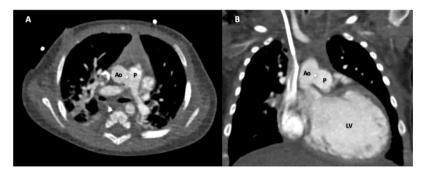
Computed tomography. Axial (A) and coronal (B) views, in which a large (10 mm×10 mm) aortopulmonary window is evident (*). The left ventricle is severely dilated. Ao: ascending aorta; P: main pulmonary artery; LV: left ventricle.
